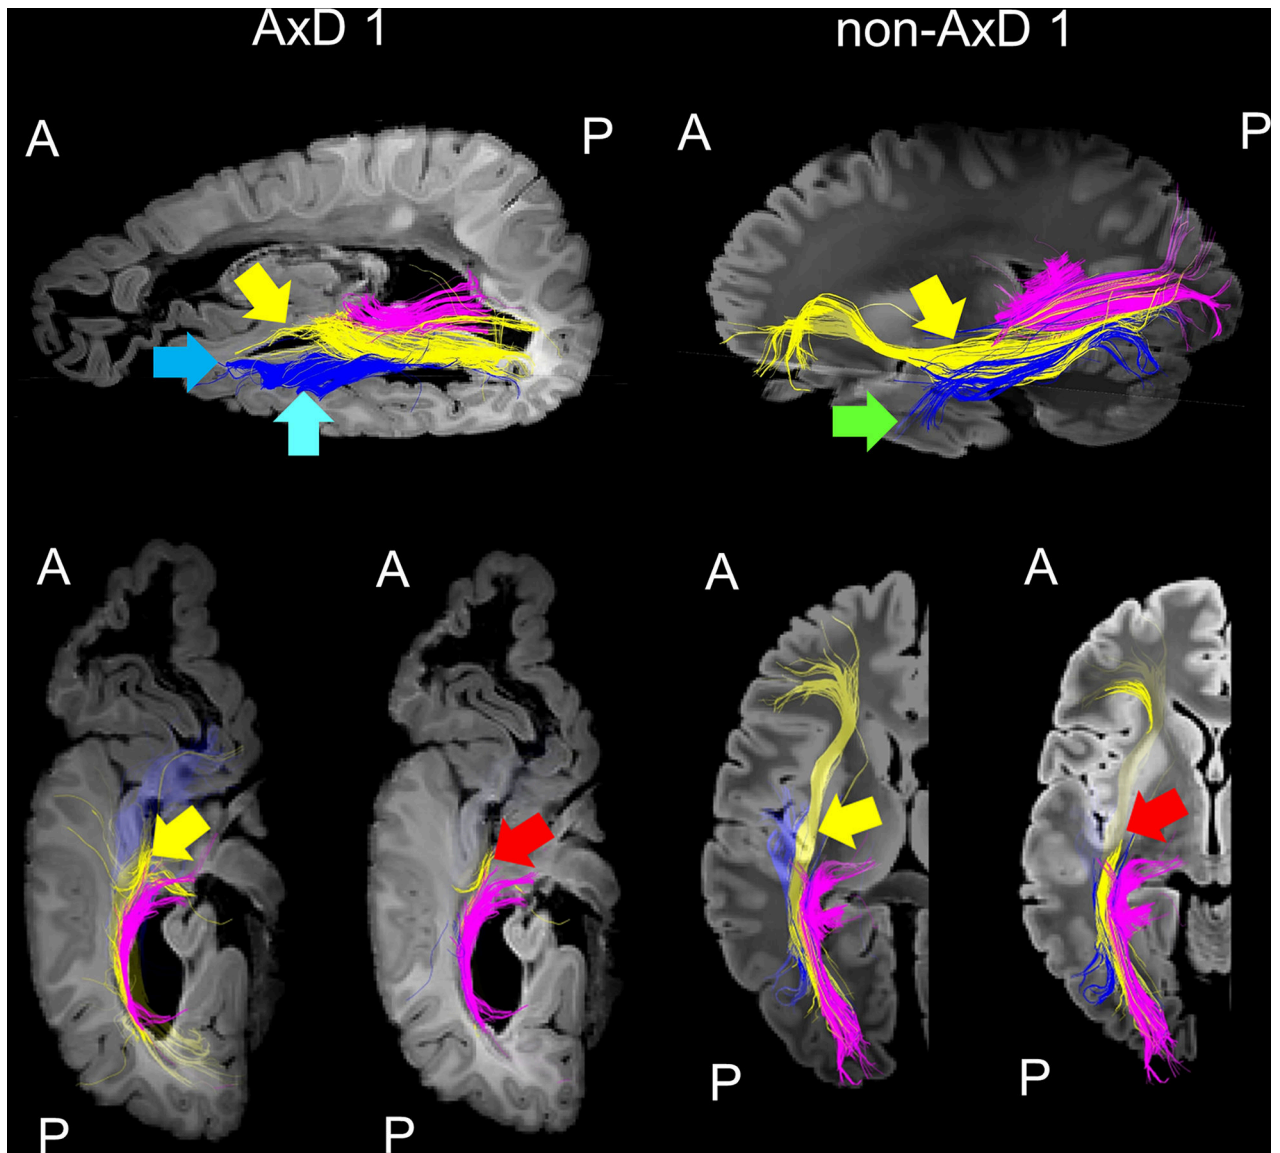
High-angular resolution diffusion MRI tractography of the left hemisphere of a 9-year-old boy with Alexander disease (AxD 1) and a 9-year-old neurotypical boy (non-AxD 1). The optic radiation pathways (pink pathways), inferior fronto-occipital fasciculus (yellow pathways, yellow arrows, dark blue arrow, red arrows), and inferior longitudinal fasciculus (blue pathways, green arrow, light blue arrow) are visualized. Abbreviations: A, anterior; P, posterior.
